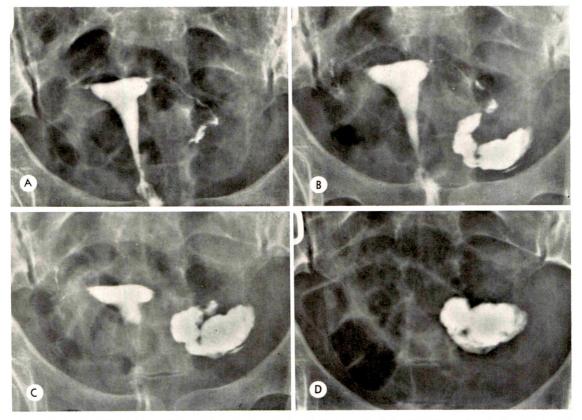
(A and B) Occlusion of the right salpinx; hydrosalpinx on the left side. Retention is demonstrated on the (C) postvoiding roentgenogram and on the (D) control roentgenogram after 2 hours.
